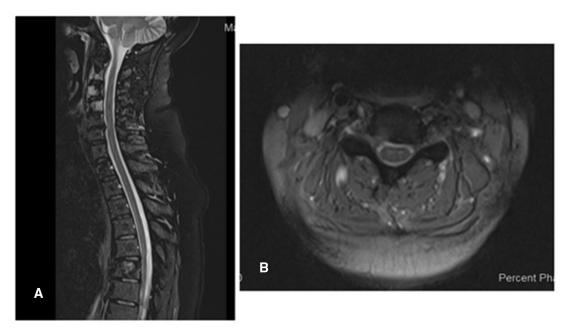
Three months after treatment. (A) T2-weighted magnetic resonance image (MRI) of the cervical spine with sagittal cut. (B) T2-weighted MRI of the cervical spine with axial cut at the C4 level revealed interval sclerosis and decreasing enhancement of the lesions at C2, C3, C4, T1, and T6.
